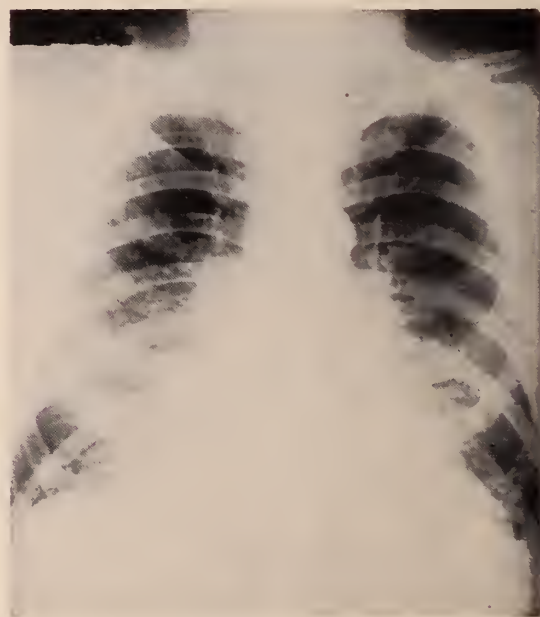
Roentgenogram, February, 1966, showing fine mottled shadows diffusely distributed throughout lower lung fields bilaterally.
